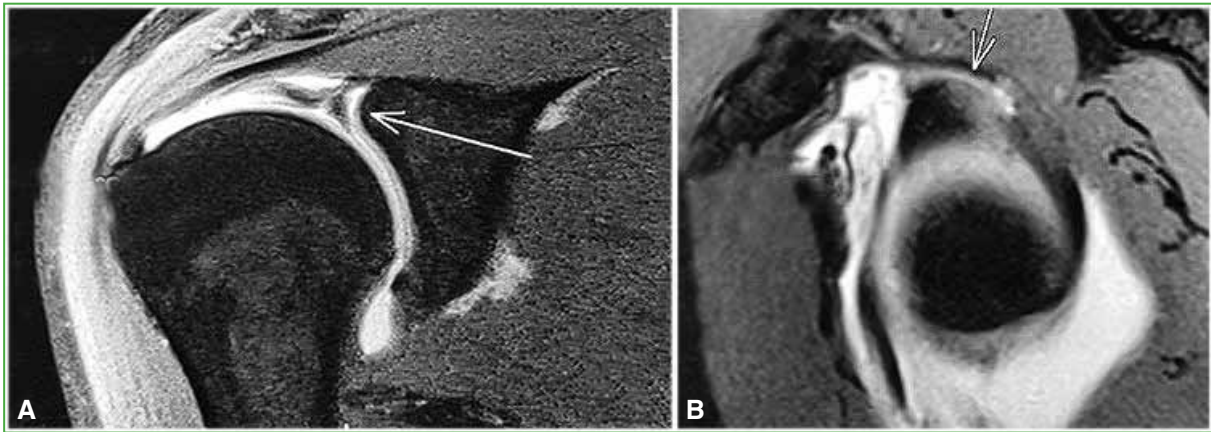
Magnetic resonance imaging of the shoulder. A. Anteroposterior section. The arrow shows a type II SLAP lesion. B. Sagittal section. The arrow shows an anteroposterior type II SLAP lesion.
